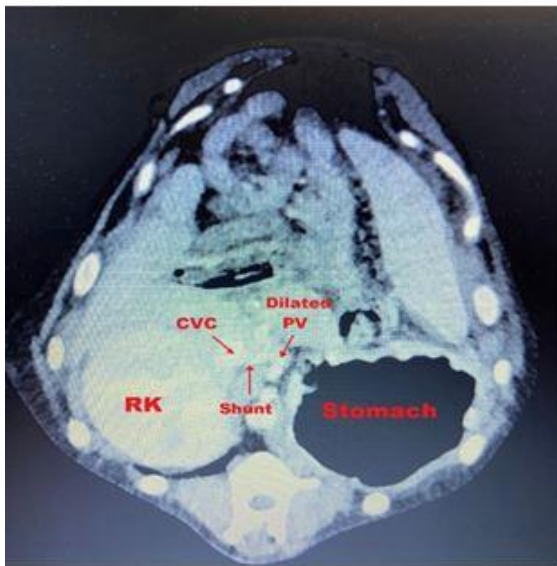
PSS on CT-imaging (RK=Right Kidney, CVC= Cranial Vena Cava, PV= Portal Vein.)
